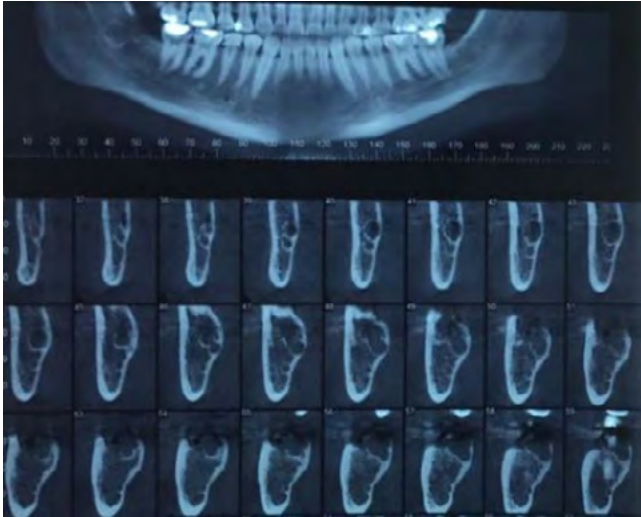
Radiographic follow-up at 36 months. No signs of recurrence or other complications were observed.
